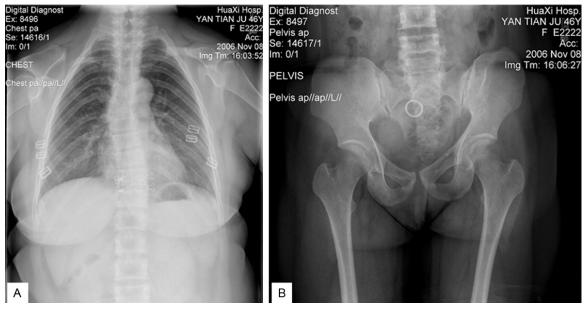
Plain radiographs: dysplastic clavicles, spine scoliosis, occult cleft and asymmetric flank bone in the mother. A: Chest; B: Abdomen.
